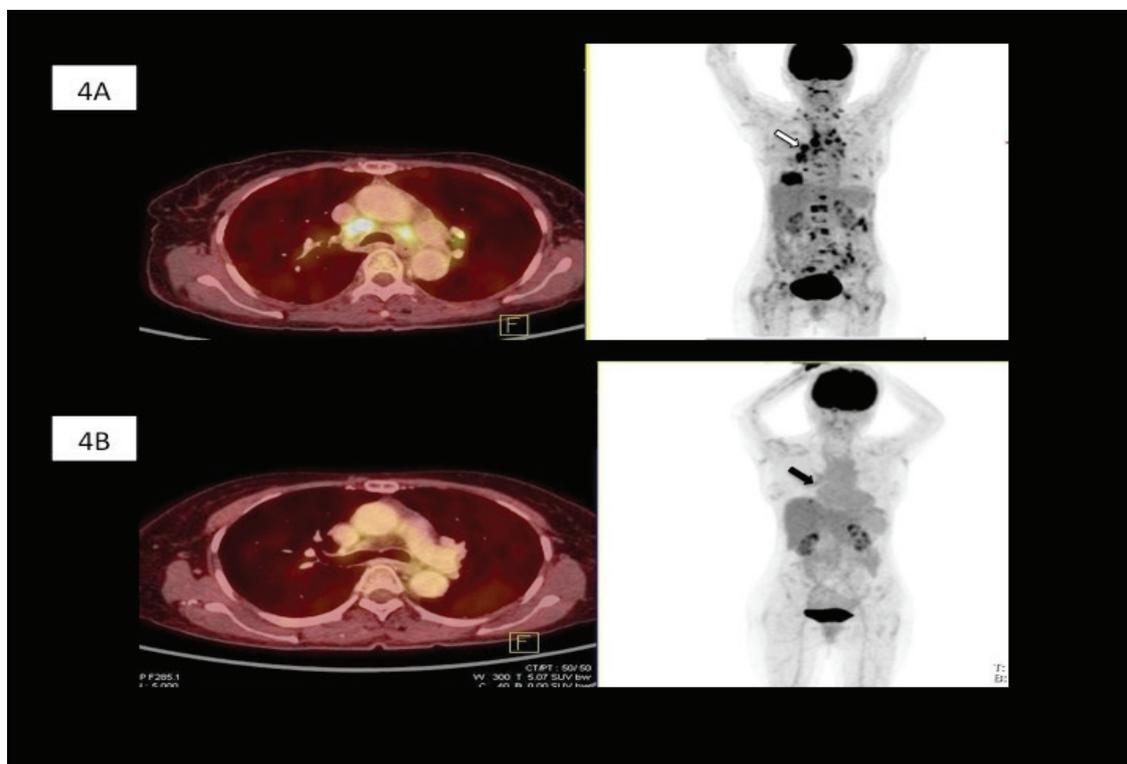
(A) Baseline PET/CT revealed a 61-year old lady with Stage IV NSCLC to have multiple lung metastases and mediastinal lymphadenopathy (white arrow). (B) Follow-up PET/CT demonstrated remarkable response to treatment with resolution of the lymphadenopathy (black arrows) no abnormal FDG uptake throughout the body in keeping with complete metabolic response (CMR).
